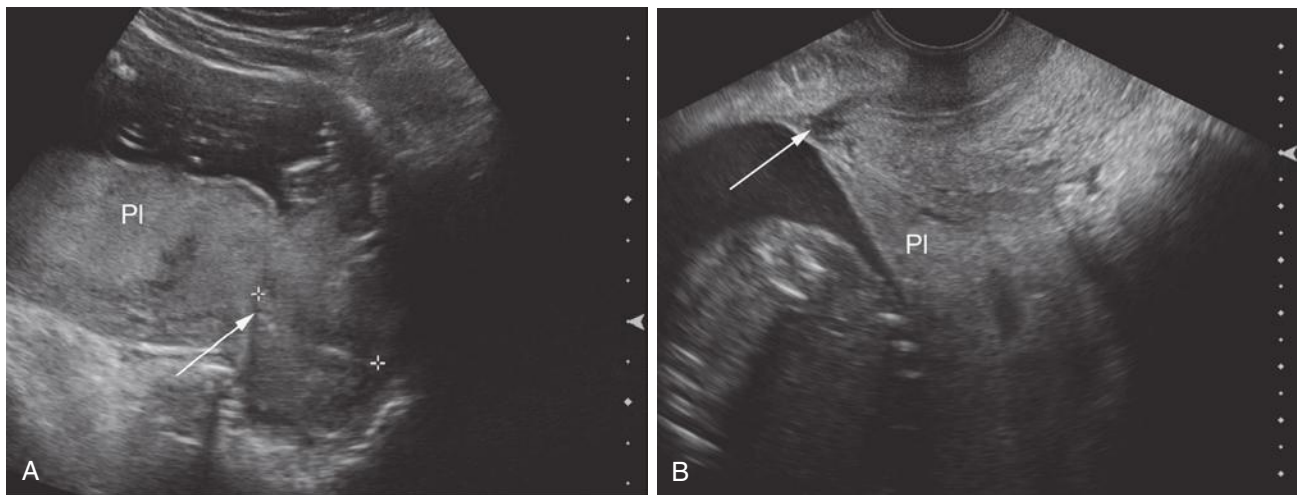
A, Transabdominal longitudinal sonogram demonstrating what appears to be complete placenta previa. The placenta (PI) appears to completely cover the internal cervical os (*arrow*). B, Transvaginal sonogram from the same patient demonstrates the placenta (PI) extends to but does not cover the internal cervical os (*arrow*).
